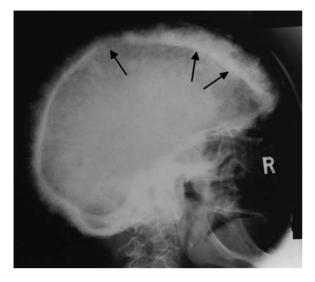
Radiograph demonstrating Paget's disease of bone. There is thickening of the skull vault and regions of lucency and sclerosis (arrows).
